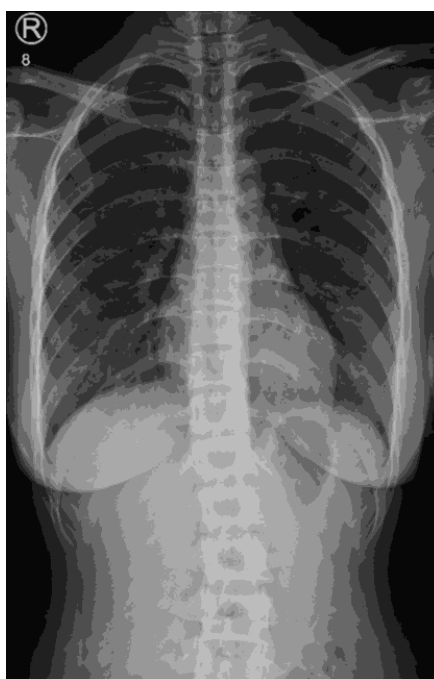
Chest X-Ray AP View.
